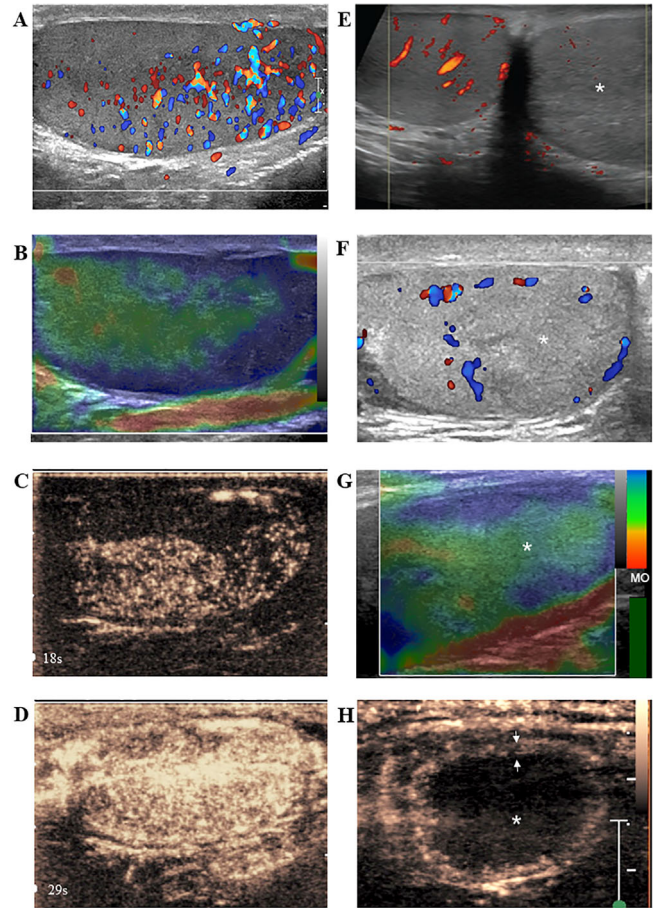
Abnormal testicular vascularisation suggesting focal orchitis, testicular torsion and segmental testicular infarction at multiparametric US. (A–D) Focal orchitis involving the lower pole and part of the midportion of the left testis in a patient presenting with left acute scrotal pain. The lower pole and the midportion of the testicular parenchyma show enhanced vascularisation at colour-Doppler US evaluation (A), hard at elastography (B), with early enhancement (18 s) after microbubble contrast injection (C). The testis enhances homogeneously within 29 s after microbubble injection (D). (E) Absent vascularisation of the left testis in a patient presenting with acute scrotal pain diagnosed as testicular torsion. Spectacle view of the testes shows no vascular spots in the left testis (asterisk) and normal vascularisation in the contralateral testis. (F–H) Segmental testicular infarction in a patient presenting with left scrotal pain for 3 days. The lower pole of the left testis (asterisk) is slightly hypoechoic and shows no colour signals at colour-Doppler US (F). The lesion (asterisk) is soft at sonoelastography (G) and avascular at contrast-enhanced US (H). A perilesional enhancing rim is appreciable (arrows in panel H)
